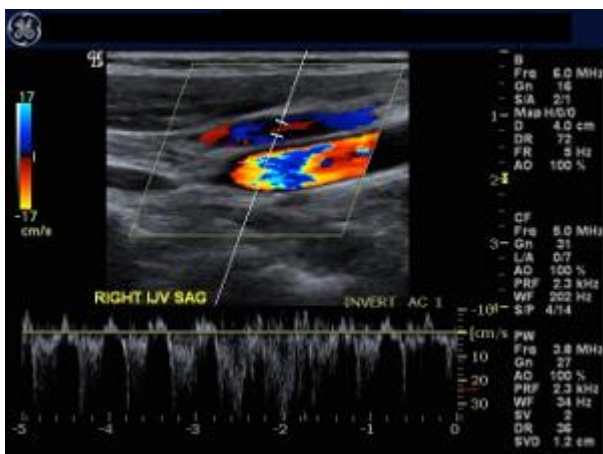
Color and Spectral Doppler image of Right Internal Jugular Vein
